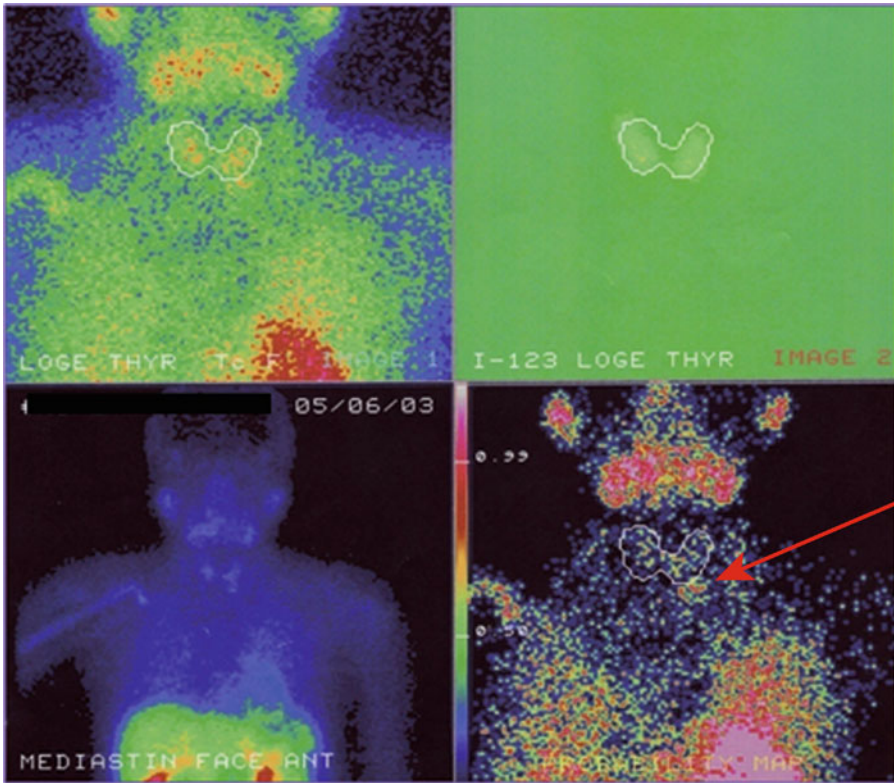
Parathyroid adenoma detected by MIBI scintigraphy in a child (arrow)
